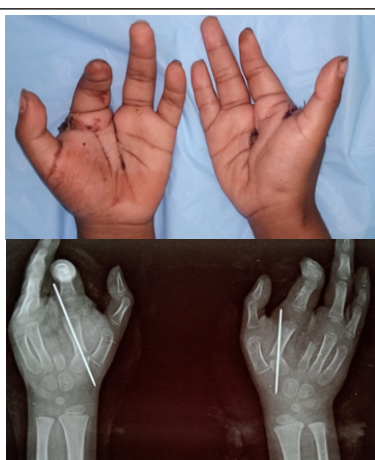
Postoperative clinical pictures and anteroposterior radiographs of both hands
